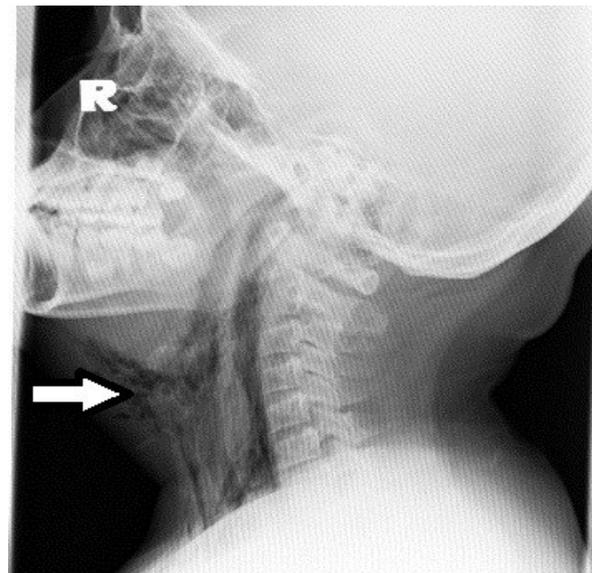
Post-operative day 2 Lateral view of soft tissue neck radiograph. Arrows show extensive cervical subcutaneous emphysema
